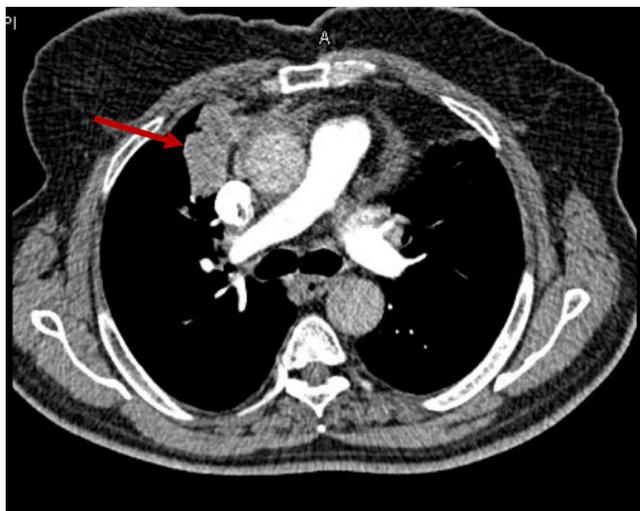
CT Chest indicating right upper lobe lesion (arrow).
